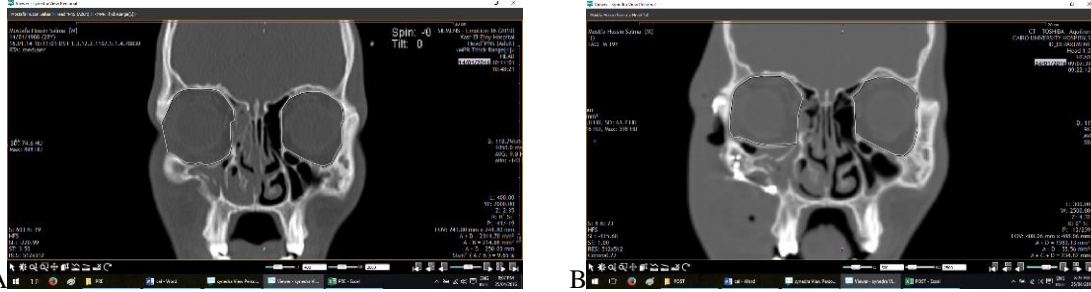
A) preoperative CT of the patient with increase in the orbital volume of the affected orbit; B) postoperative CT of the same patient after repair with proper bony alignment and approaching the volume of the normal eye
